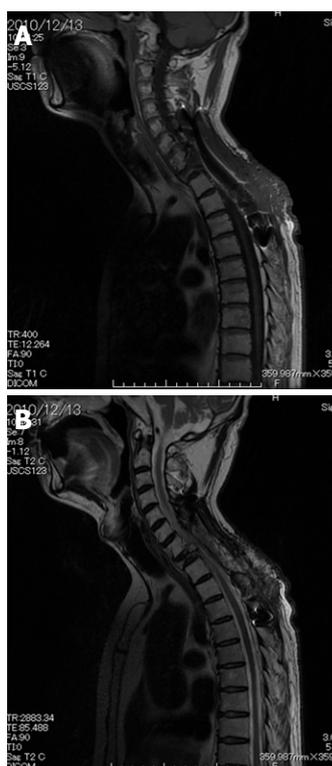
Magnetic resonance imaging showing the pseudomeningocele had disappeared 3 mo after closure of the cerebrospinal fluid leak. A: T1-weighted image; B: T2-weighted image.
